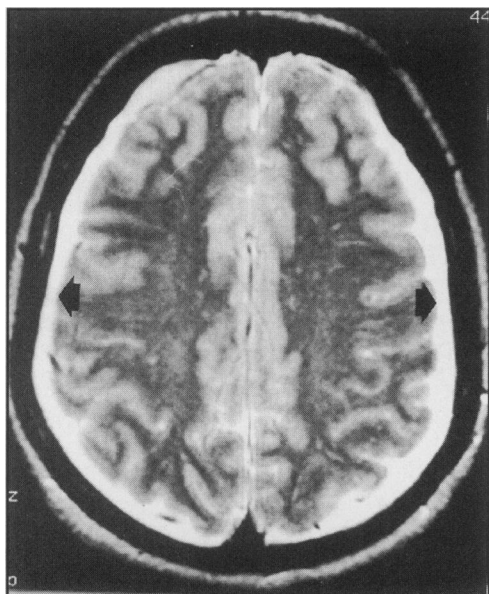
(a) T2-weighted axial MR scan showing bilateral hyperintensity in the subdural spaces suggesting subdural collections (arrowheads).
